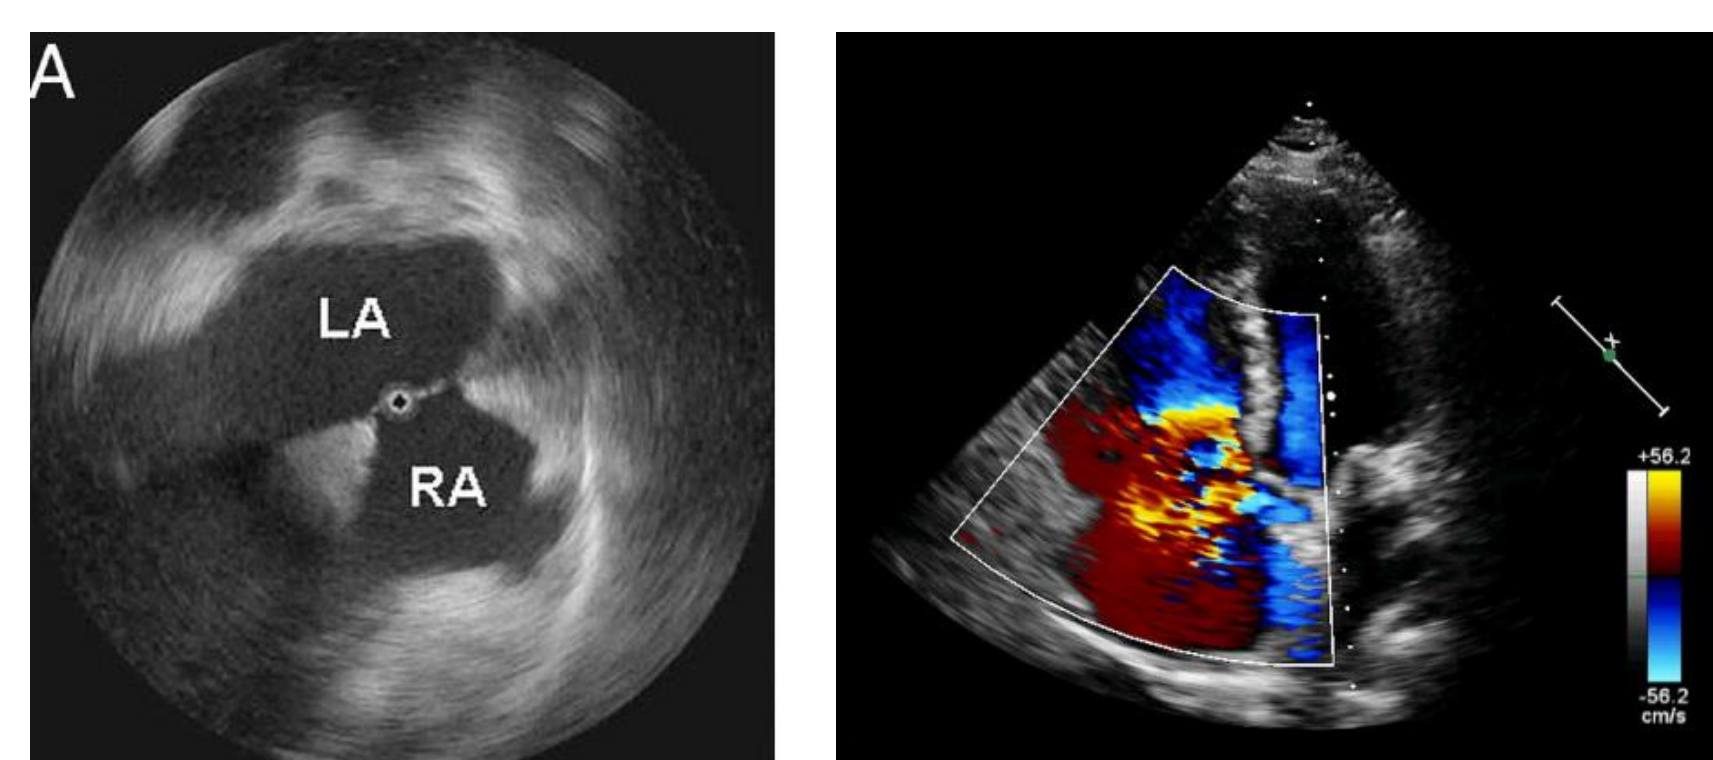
(A) Radial ICE image and (B) Color Doppler seen on a Phased Array ICE Image [2]
